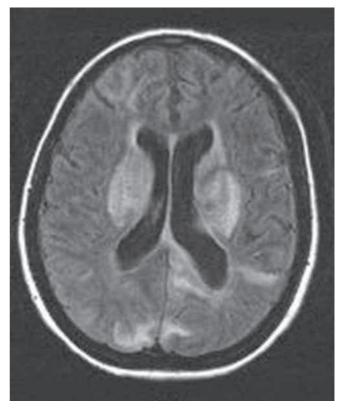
Brain MRI-T2/FLAIR showing T2 subcortical hyperintensity without enhancement in parieto-occipital lobes before treatment.
